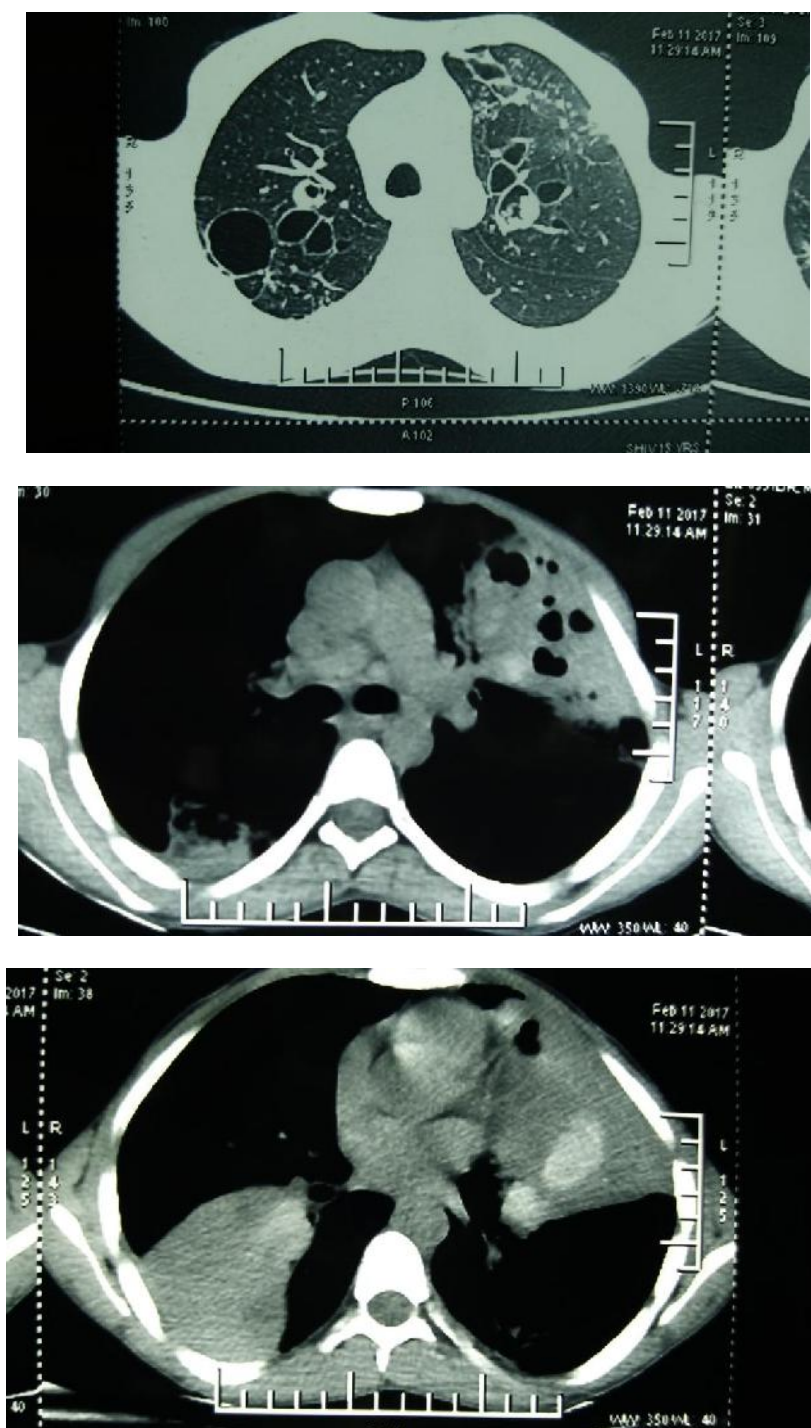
Lung and Mediastinal windows of the HRCT scans showing evidence of central bronchiectasis and mucus filled bronchi which involved both the lungs.
